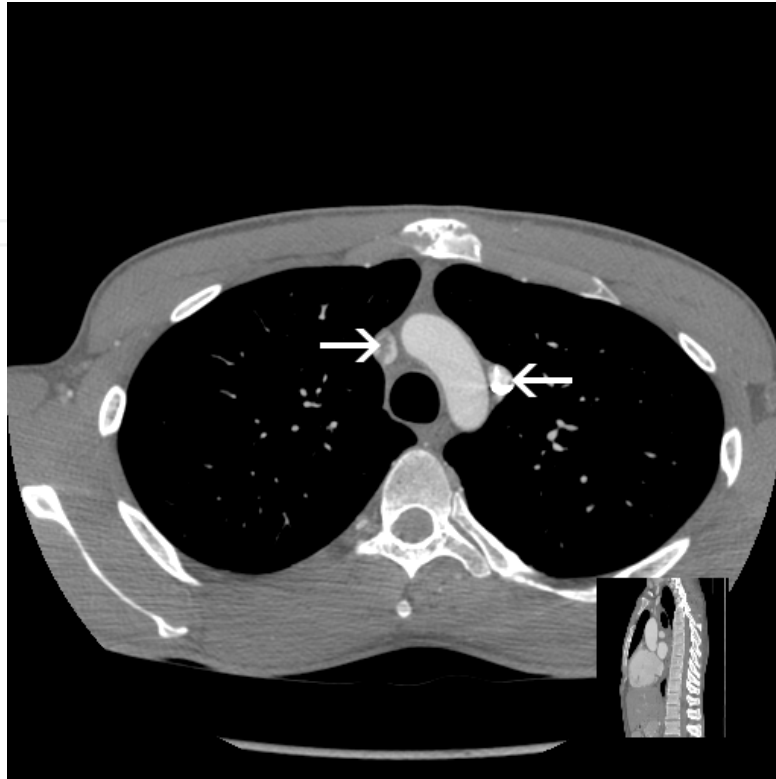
Axial CT image presents bilateral superior venae cavae (arrows).
